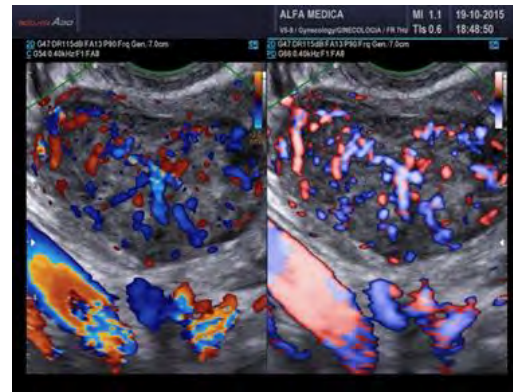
LMS Note the heavy doppler signals not around the mass but also inside. (Doppler (left) and Power Doppler (right) intensities)
